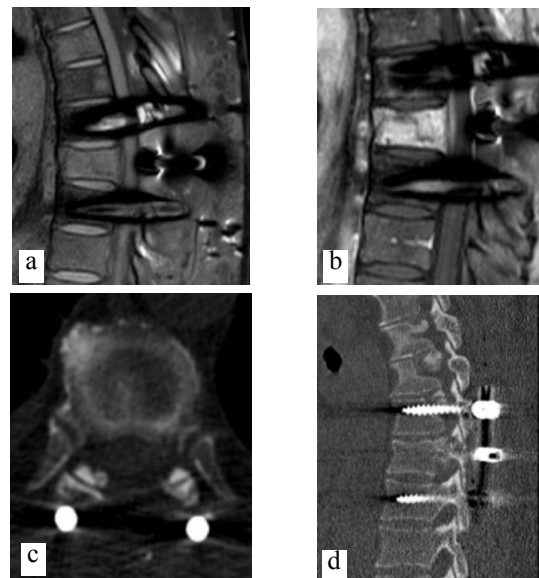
Magnetic resonance imaging (MRI): a and b T1-weighted after gadolinium administration and STIR images, showing the reduction of volume of T8 vertebral body, with reduced impingement on the spinal cord. c and d Computed tomography (CT) scan of the thoracic spine showing a local posterior decompression and the transpedicle fixation in T7-T9.
